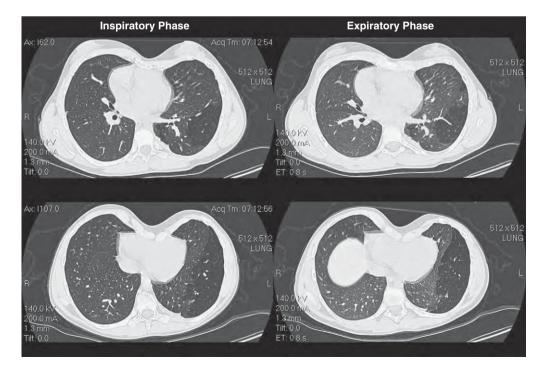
A 12-year-old girl with irreversible obstructive lung disease consistent with bronchiolitis obliterans (Swyer-James changes). Large hypolucent areas of the left lower lobe are noted which become more prominent on expiratory phase CT scan. Failure of these areas to compress significantly during expiratory phase is consistent with air-trapping. (Child also has moderate pectus excavatum. The round opacity within the right lung field of the lower right CT scan is the diaphragm extending upward during expiratory phase.)
